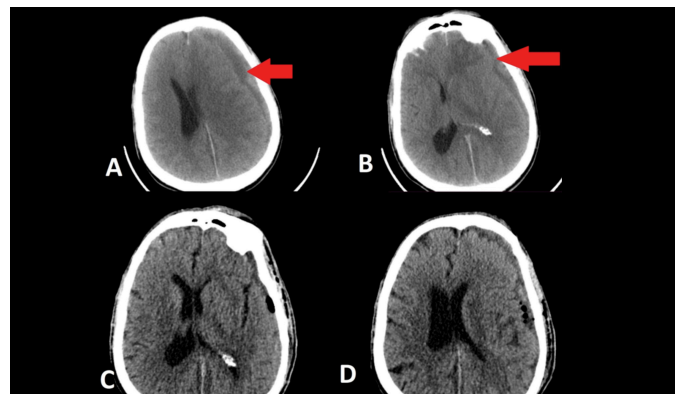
Fifty-eight year old with history of warfarin use. (A, B) Preoperative CT brain. Red arrows point to left-sided hypodense subdural collection with tense brain and midline shift. (C, D) Postoperative images after subgaleal drain placement shows significant reduction of mass effect and hematoma volume. The drain can be noted tracking in subgaleal space overlying the bone.
